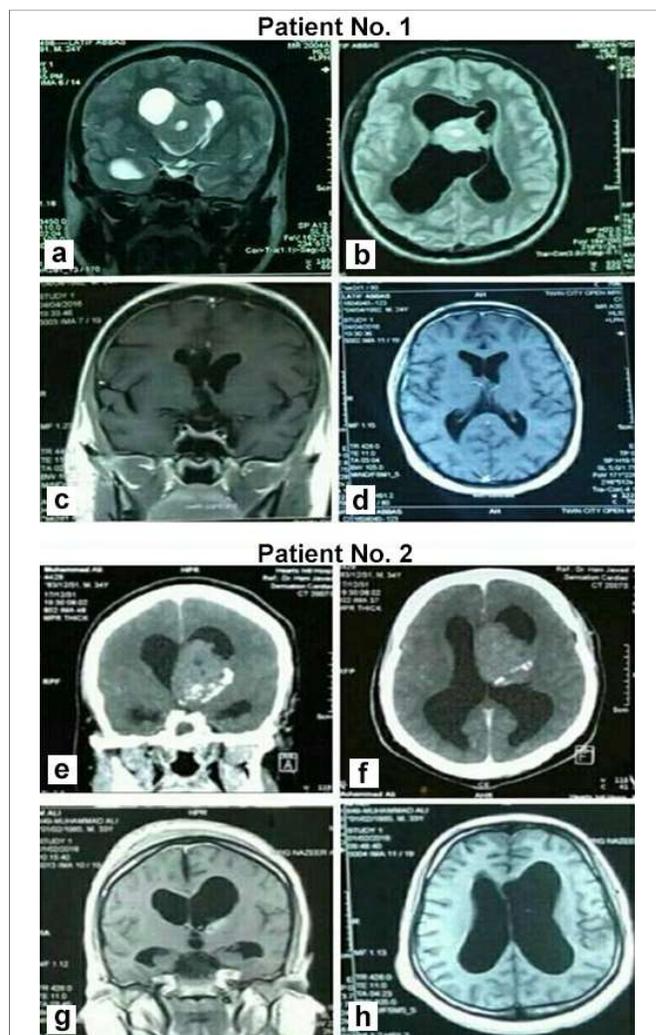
Patient 1: Preoperative T2W-MRI brain coronal (a) T1W-MRI axial sections (b) large right intraventricular tumor, gross dilatation of right lateral ventricle, compression the left lateral ventricle. Postoperative T1W-MRI brain scans (c) coronal (d) axial sections showing successful complete resection, with no residual tumor.
